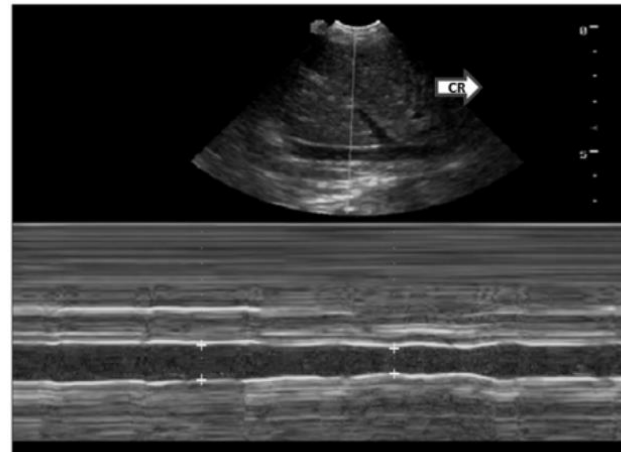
Measurement of the maximum and minimum diameter of the caudal vena cava using the inner method by ultrasonographic M mode. The M mode is placed near to the insertion of the right hepatic vein into the caudal vena cava. Cr, cranial
